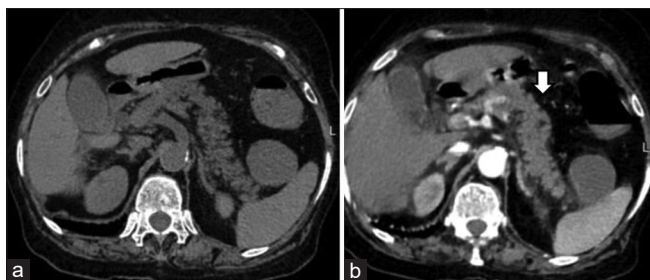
A 68-year-old male presented with complaints of acute onset epigastric pain and history of gallstone disease. NLR was 2 (normal). (a) NCCT shows bulky pancreas with mild peripancreatic fat stranding. (b) On contrast CT pancreas shows homogeneous postcontrast enhancement (white arrow). MCTSI score was 2 (Mild). Patient did not develop any organ failure and severity grade according to RAC was also mild. Patient was discharged in 6 days without any adverse clinical outcomes
